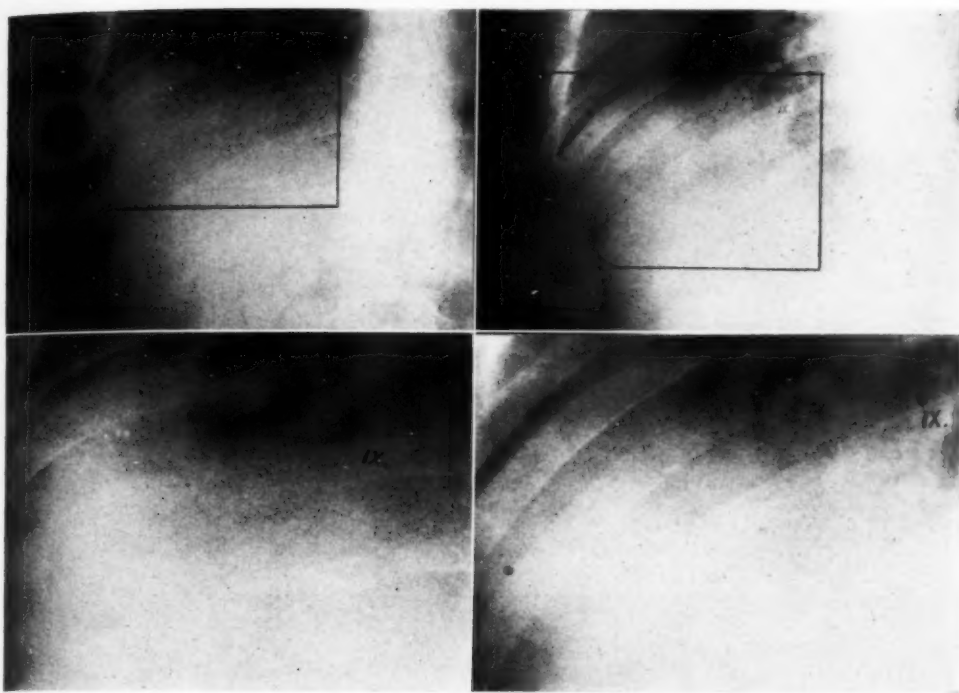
Anteroposterior and oblique views (with magnifications below) of ribs fifteen days after injury and two weeks after initial roentgenograms, showing a fracture of the right 8th rib with fairly wide gap. No fracture of the 9th rib is seen.
